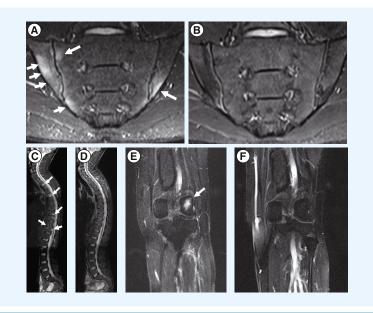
Examples for MRI before and after 48 weeks of treatment with etanercept. Sacroiliac joints: (A) Baseline MRI sacroiliac joint score 15.5 and (B) week 48 MRI sacroiliac joint score 0. Spine: (C) baseline MRI spine score 11.5 and (D) week 48 MRI spine score 1. Enthesitis of lateral condyle of femur of right knee (dorsal view): (E) MRI baseline with enthesitis and (F) week 48 without enthesitis.
